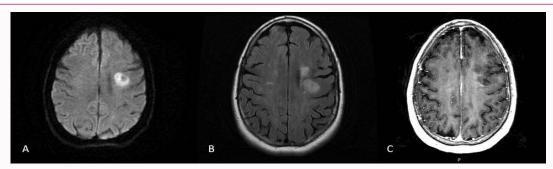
Brain MRI acquired in January 2023 showing lesion characteristics on (A) axial diffusion-weighted image, (B) axial FLAIR sequence image and (C) axial T1-weighted post-contrast image.
